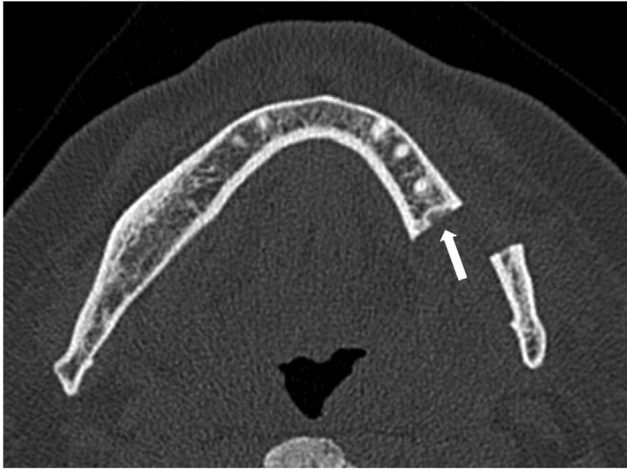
Preoperative CT findings. Case 2: Cortical bone around the extraction socket remained (white arrow).
